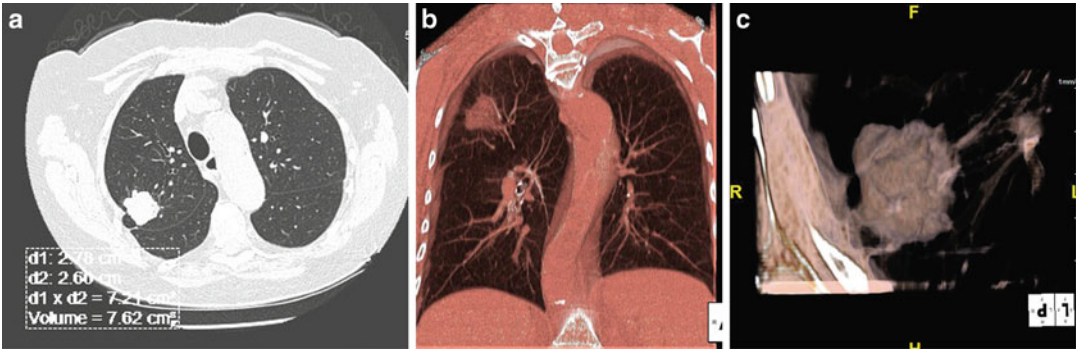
Volumetric imaging. (a) Axial CT image shows automated nodule segmentation with calculation of nodule volume. (b) Thick slab volume rendered image of same nodule. (c) 3D volume rendered image
